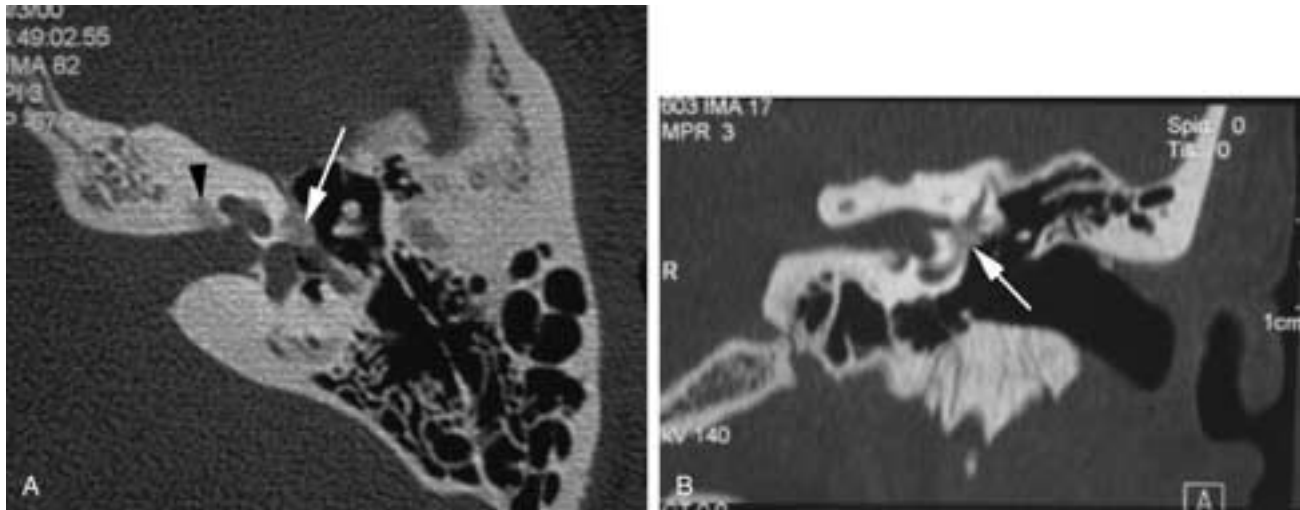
Otosclerosis, CT scan. A, Axial slice through the labyrinth shows a demineralization (*arrow*) just anterior to the footplate of the stapes. Note that the small area of demineralized bone has actually increased in volume. This patient had a component of cochlear otosclerosis. Note the area of demineralization (*arrowhead*) just medial to the cochlea. B, Coronal image shows the demineralized bone (*arrow*). This slice is just anterior to the oval window.
